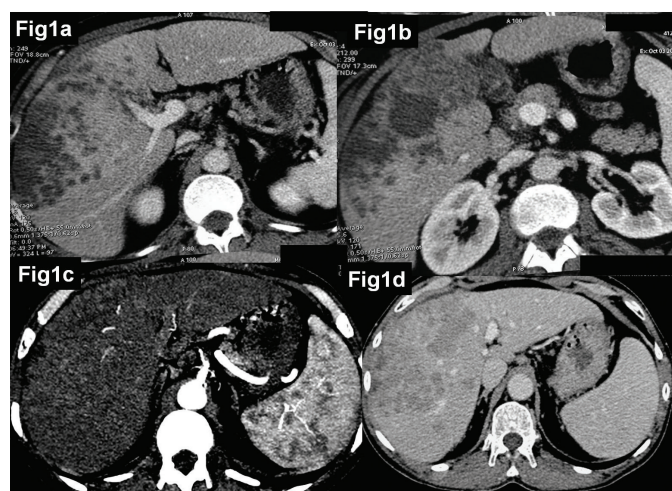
(a and b) Triphasic CT abdomen showing a large 12 x 8 x 12cm lesion occupying segments V, VI, VII, VIII, with multiple well defined lesions in segment VII, VIII and IV. (c and d) PET-CT scan showing infiltrative poorly margined complex cystic nodular pattern mass involving most of the right lobe, another subcentimeter lesion in segment IVa. This lesion was enhancing in arterial phase and showed a washout in equilibrium phase.
